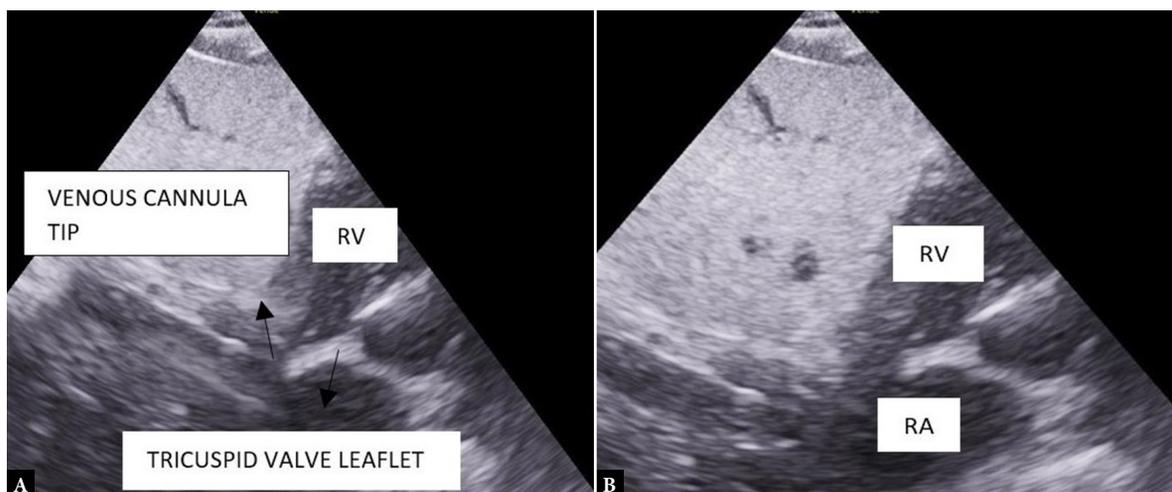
Subcostal 2D echocardiography view. A. Venous cannula tip abutting the tricuspid valve leaflet. B. After venous cannula repositioning at inferior vena cava and right atrial junction. RA – right atrium, RV – right ventricle
